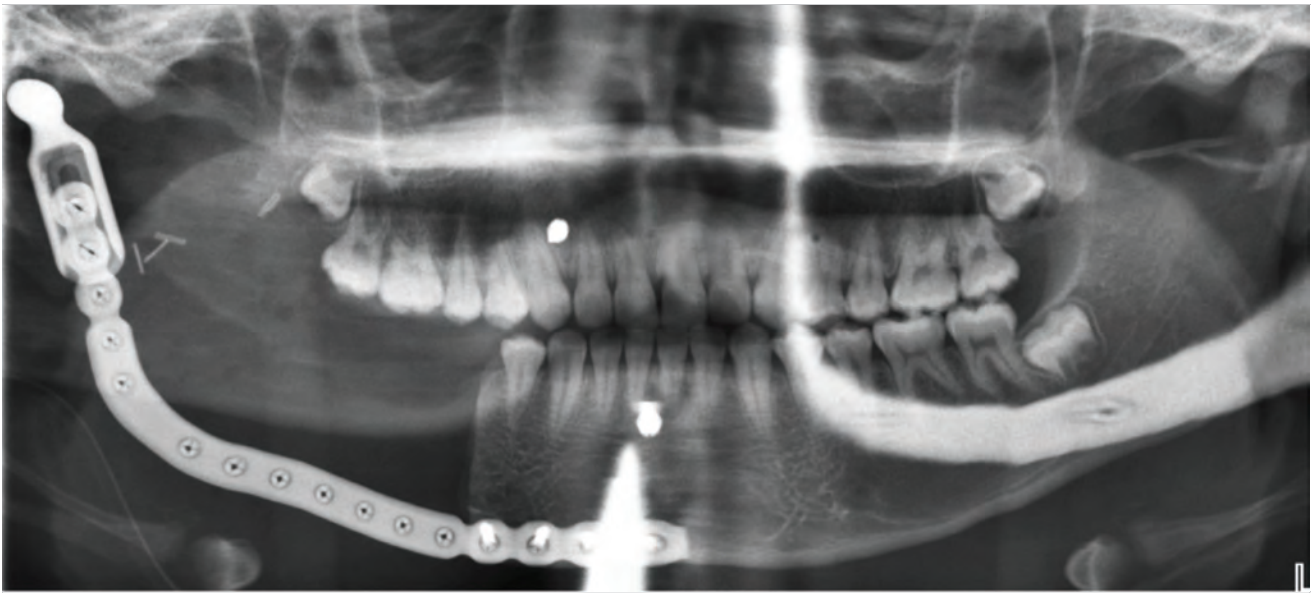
Postresection radiograph.
